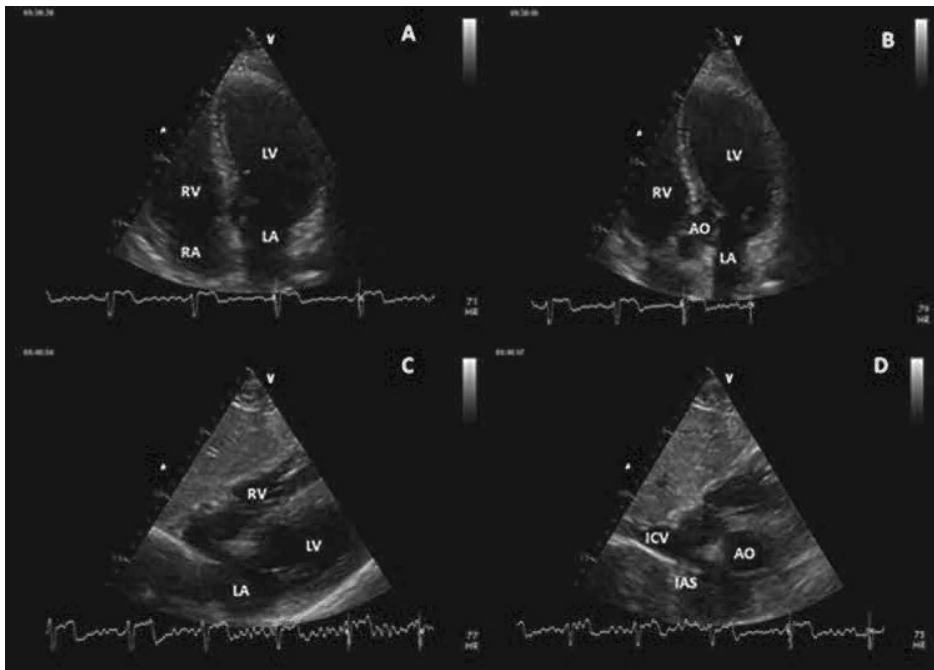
Apical 4-chamber (A), 5-chamber (B), and subcostal windows (C, D) showing left and right chambers, inferior cavae vein, and pericardium. *LV*, left ventricle; *LA*, left atrium; *RV*, right ventricle; *RA*, right atrium; *AO*, aorta; *IAS*, interatrial septum; *ICV*, inferior cava vein.
